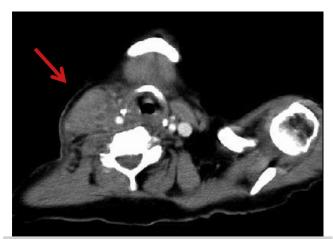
Computed tomography (CT) scan demonstrating right internal jugular vein (IJV) thrombosis and adjacent abscess (*red arrow*).
